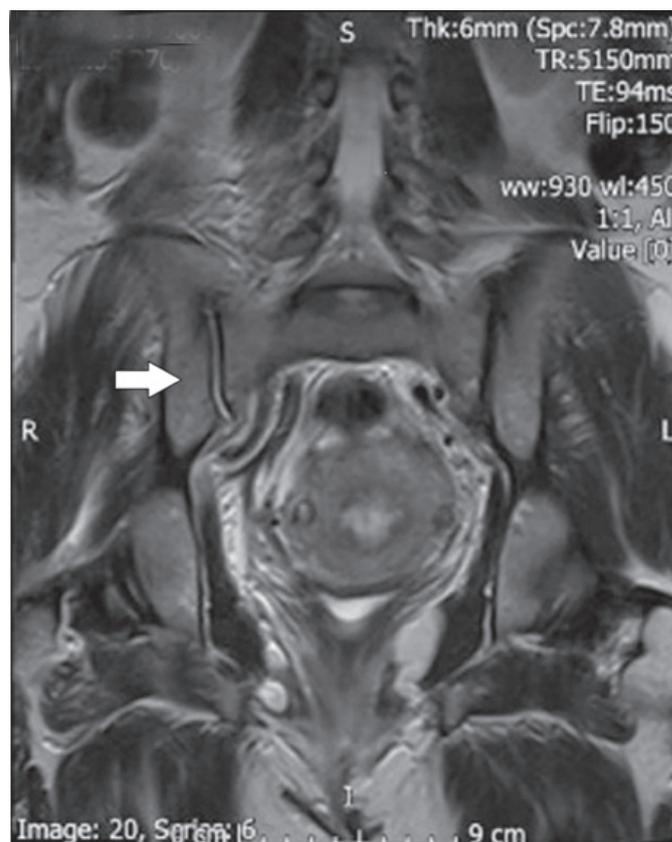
Magnetic resonance imaging scan of pelvis, coronal T2 demonstrating high signal in the right sacroiliac joint. The arrow shows high signal fat on the T2 in the right sacroiliac joint and fluid filled structure extending anteriorly from the right sacroiliac joint.
